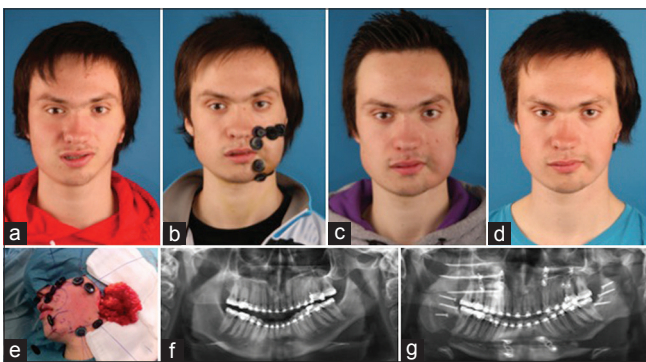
Pruzansky-Kaban Type IIa. (a) Frontal view after orthodontic preparation; (b) frontal view after facial rotation and free fat grafting; (c) frontal view six months after free fat grafting; (d) frontal view one year after free fat grafting; (e) gluteal fat tailored after facial requirements, ready to be inserted via a "short scar facelift" incision; (f) orthopantomogram after orthodontic preparation; (g) orthopantomogram immediately after the facial rotation procedure (note the massive chin osteotomy displacement)
